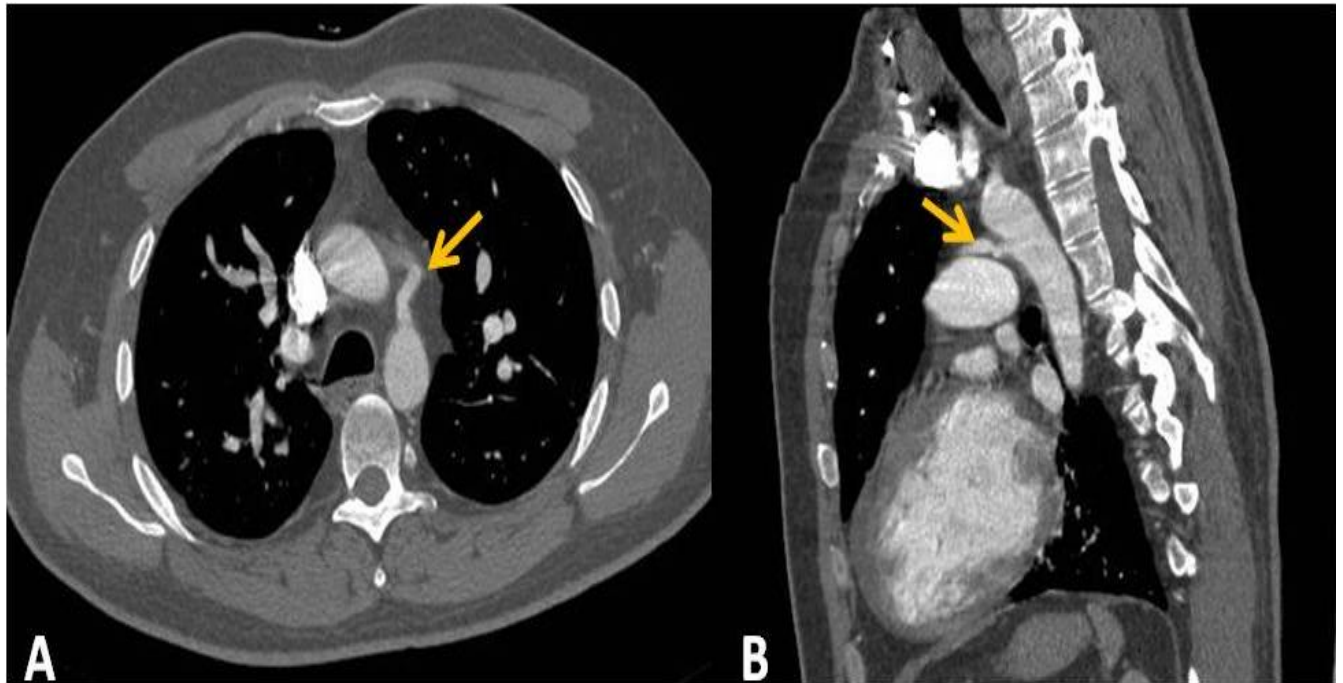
Axial (A) and sagittal CT (B) images shows a patient with PAH secondary to congenital heart disease- patent Ductus Arterious communicating between the aorta and pulmonary trunk (A)
